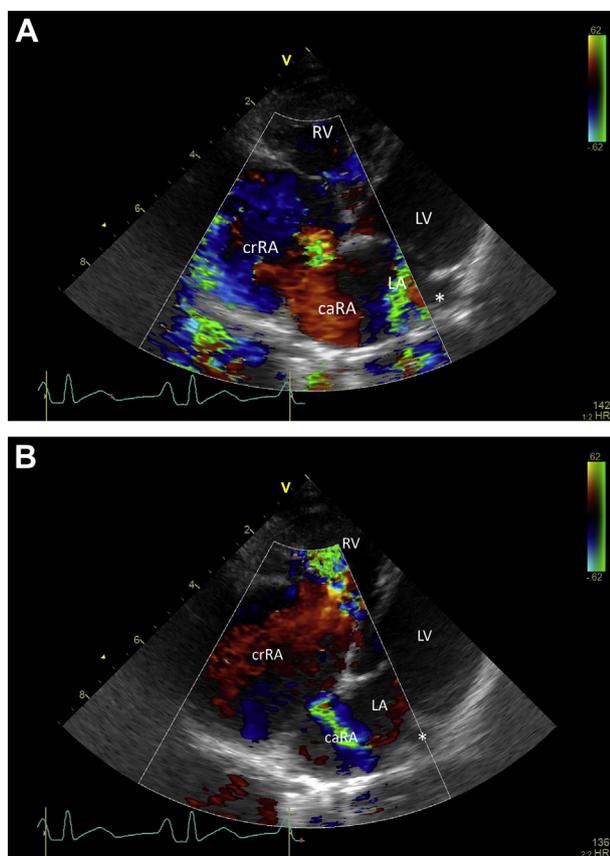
Two-dimensional and color Doppler echocardiographic image from the left apical imaging window obtained during systole (A) and during late diastole after atrial contraction (B). In (A), antegrade blood flow is visualized from the caudal right atrial (caRA) into the cranial right atrial (crRA) chamber. Turbulent blood flow in the left atrium (LA) representing mitral regurgitation is also demonstrated. In (B), the flow across the membrane has reversed with flow from the crRA now entering the caRA. Turbulent inflow across the tricuspid valve as a result of tricuspid valve stenosis is also observed. RV, right ventricle; LV, left ventricle. *Dilated coronary sinus.
